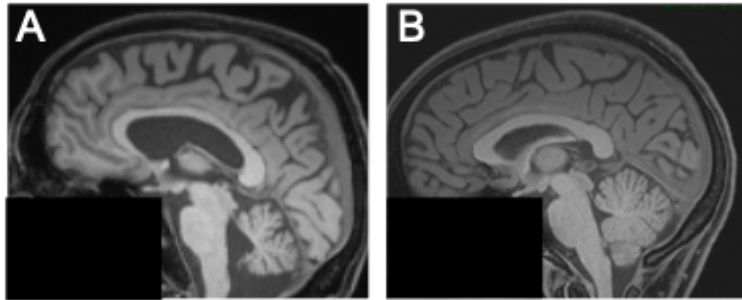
Atrophic or not? In advanced cases of gray matter loss (as evident by the deep sulci of the 57-year-old female subject shown in A), atrophy can be easily identified by visual inspection (compare e.g. to the relative “dense” packing” of the healthy 23-year-old subject in B with no evident atrophy). However, when atrophy is more subtle, it is not so straightforward to determine and highly subjective. In this dissertation, we propose and validate an objective and reliable tool to detect signs of atrophy for individual patients in a computational and automatized procedure, which uses merely a T1-weighted MRI image along with demographic information on age and gender. The procedure yields high-resolution maps of supposed atrophy which we hope will aid diagnosis / prognosis of neurodegenerative diseases in a inter-rater-independent fashion, which could also serve as a new endpoint in clinical trials.
